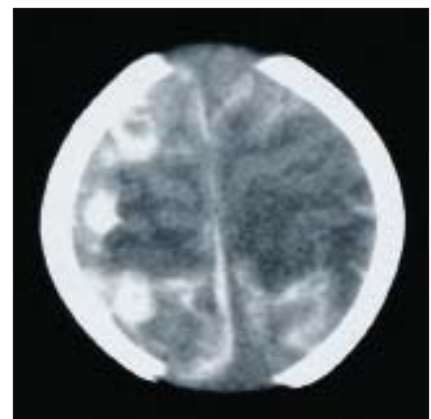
Two-week-old female with subdural, subarachnoid, and intraparenchymal hemorrhage on multislice (5 mm) cranial CT.
